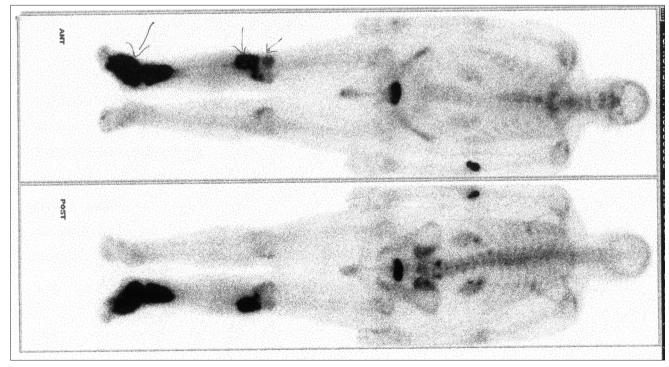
Bone scintigraphy of the whole body (metastasis to the foot bone and knee)
